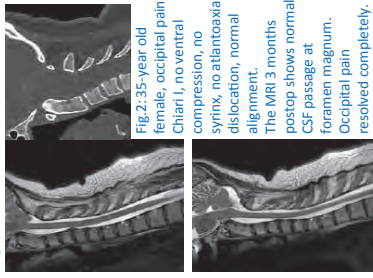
35-year old female, occipital pain, Chiari I, no ventral compression, no syrinx, no atlantoaxial dislocation, normal alignment. The MRI 3 months postop shows normal foramen magnum. Occipital pain resolved completely.
